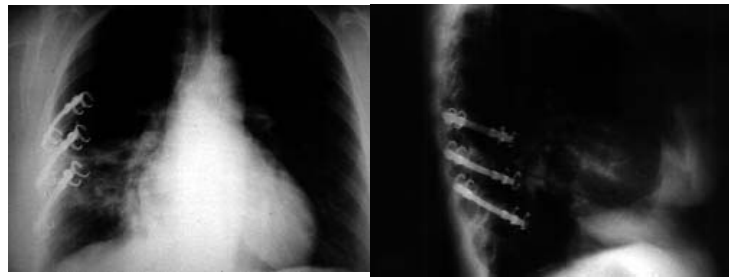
X-rays after transection, frontal and profile, and mending of 6th, 7th and 8th costal arches.
